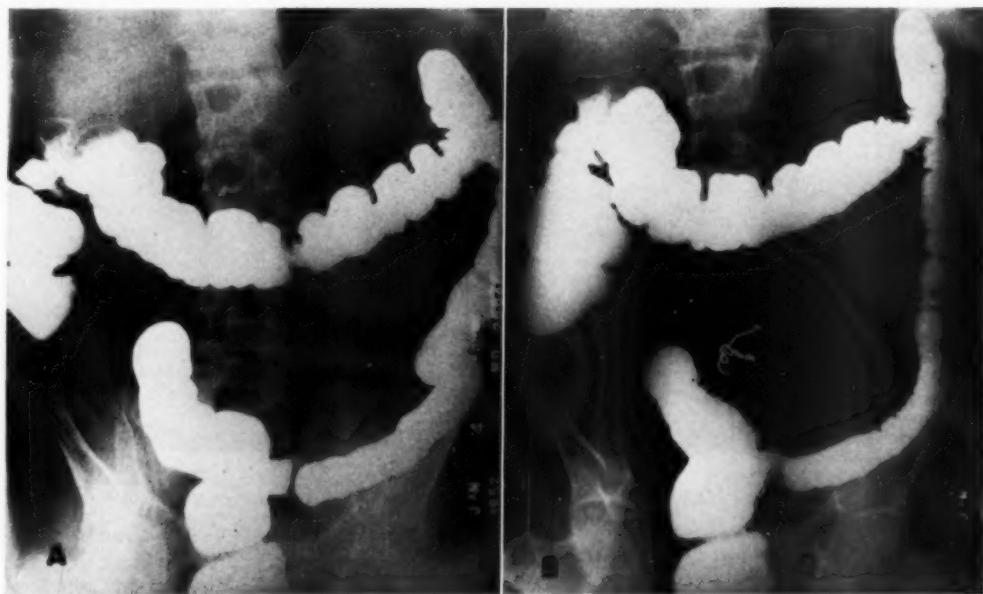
Case 2. Roentgenograms of the colon (barium enema study) to show non-visualization of segments of the ceco-ascending and descending colon without flank compression and visualization of both missing colon segments after flank compression.
